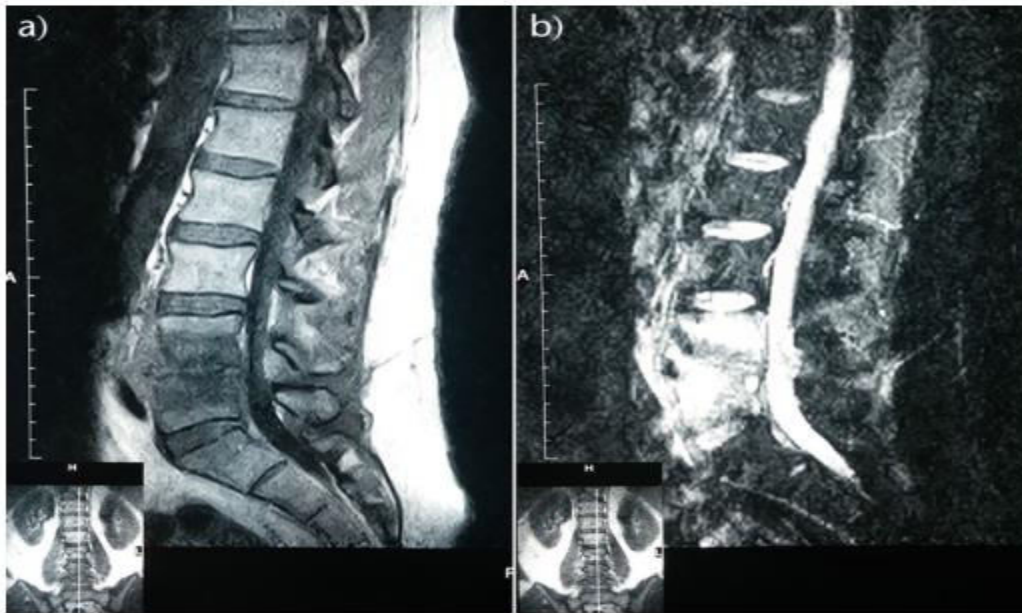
Sagittal (a) T1-weighted and (b) T2-weighted MRI of the lumbar spine of a 45-year-old patient with spontaneous pyogenic spondylodiscitis showing reduction of the L4 to L5 vertebral disc height and erosion of the adjacent vertebral end-plates (42).
